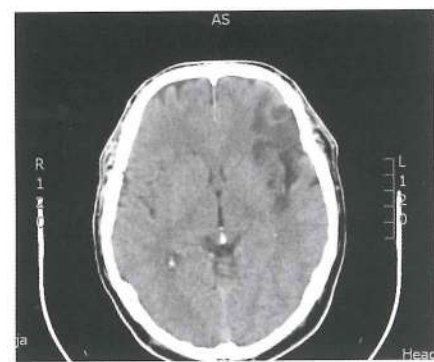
Ischemic stroke in frontal lobe (by computed tomography) in patient with Broca's aphasia
